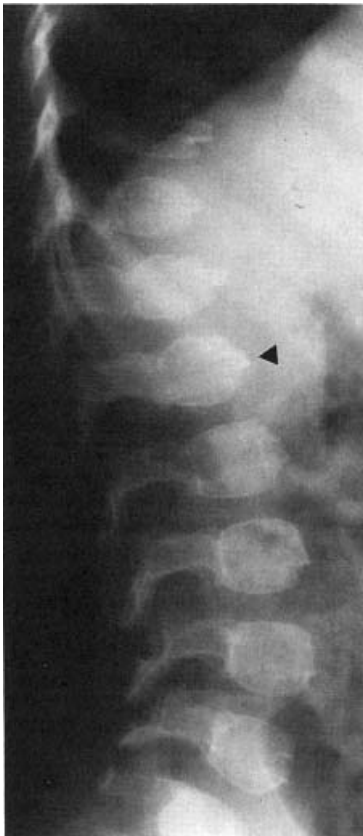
Lateral radiograph of the spine of a 3-year-old with pseudoachondroplasia (PSACH), showing the ovoid shape of the vertebral bodies with anterior tongue-like projections (arrowhead).
